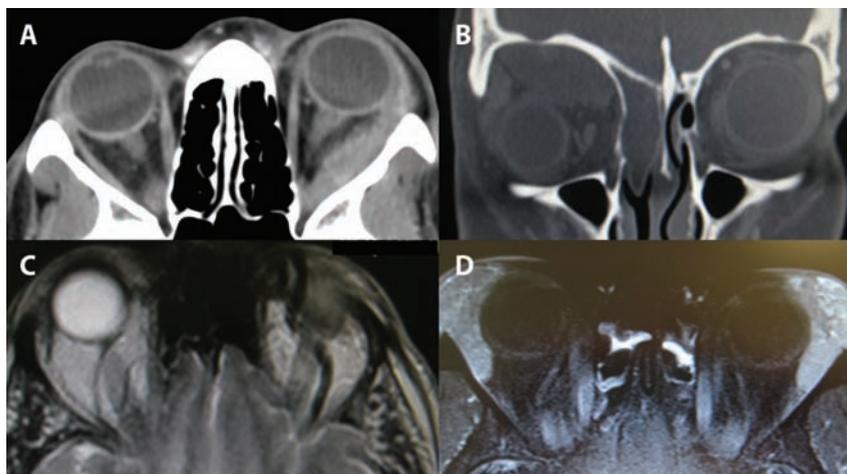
A) Contrast CT, axial view demonstrating tendon-involving enlargement of left lateral rectus muscle, more consistent with idiopathic orbital inflammation. B) Noncontrast CT, coronal view demonstrating a large abscess along the roof of the right orbit. Associated sinus disease is also shown. C) MRI with gadolinium, axial view demonstrating significantly enlarged left superior ophthalmic vein suggestive of a C-C fistula. D) MRI with gadolinium, axial view demonstrating bilateral enlargement of the lacrimal glands. Biopsy was consistent with sarcoidosis.
